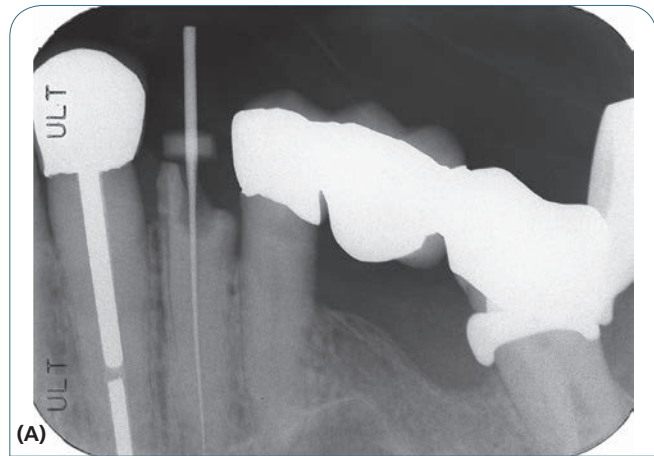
(A) When an x-ray is positioned for an endodontic radiograph, the patient does not close on the film holder because the reamer in the root canal is beyond the line of occlusion. The radiograph shows the reamer in place. (B) Patient with endodontic film holder positioned for exposure.
